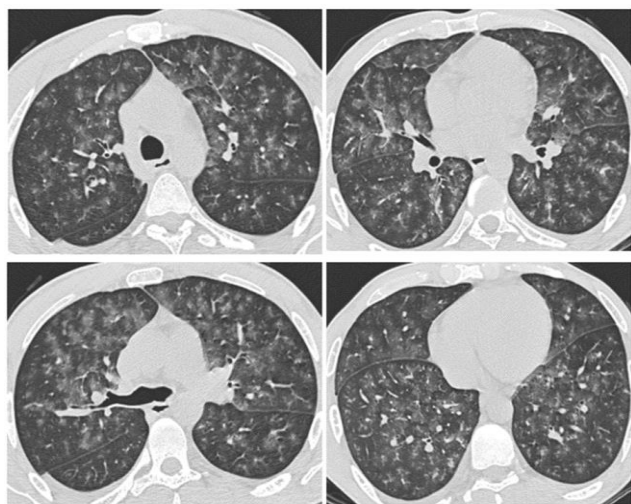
Bilateral ground-glass opacities seen on thorax CT on the 5th day of hospitalization
